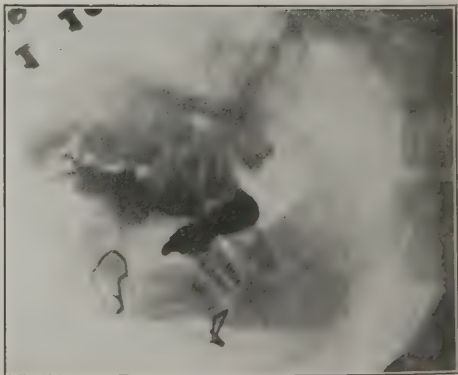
Case 12: Radiograph of other side showing similar condition.
